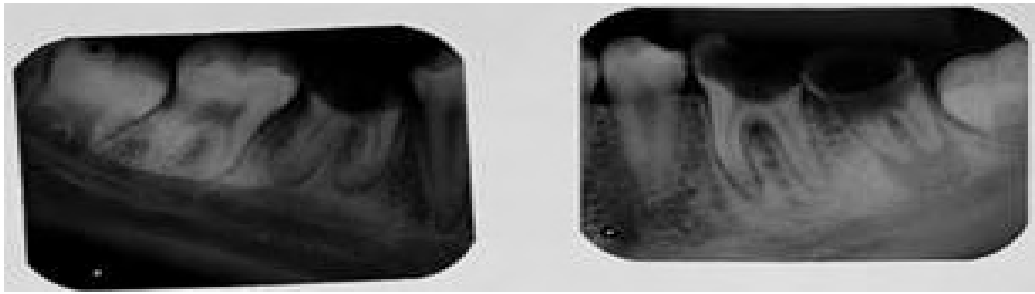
Initial periapical radiographs.
